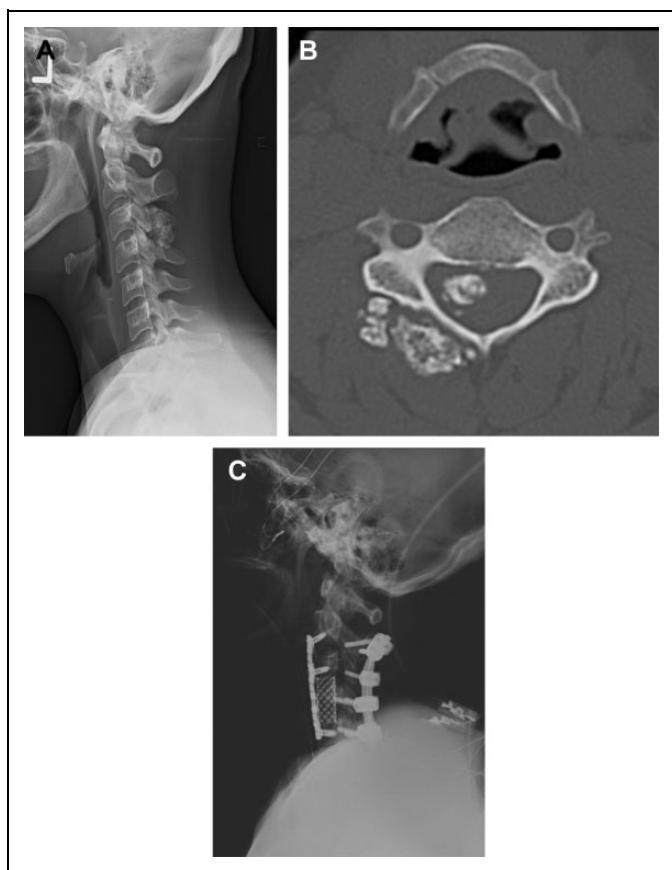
(A) Lateral radiograph and (B) axial computed tomography scan showing osseous mass arising from the right C3 lamina and invading the spinal canal causing cord compression. Biopsy revealed an osteochondroma. (C) Postoperative lateral radiograph showing C3 vertebrectomy, anterior reconstruction with a titanium cage and plate, and a posterior instrumented fusion from C2 to C5 required to stabilize the spine following a wide resection of the osteochondroma.
